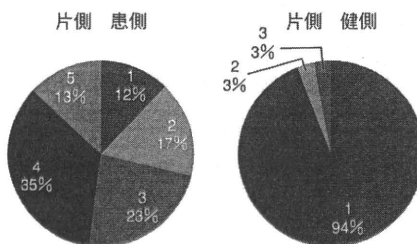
Types of lymphoscintigraphic images in the unilateral lymphedema
